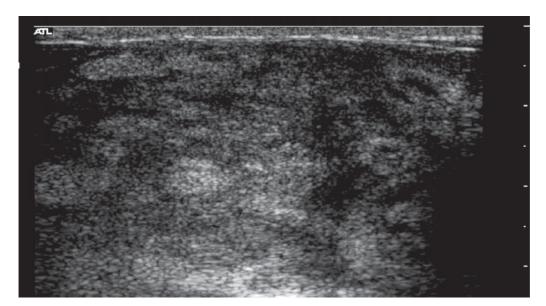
Sonography of the left breast shows diffuse, abnormal, mixed hyperechogenic and hypoechogenic regions with involvement of the subcutaneous tissue.
